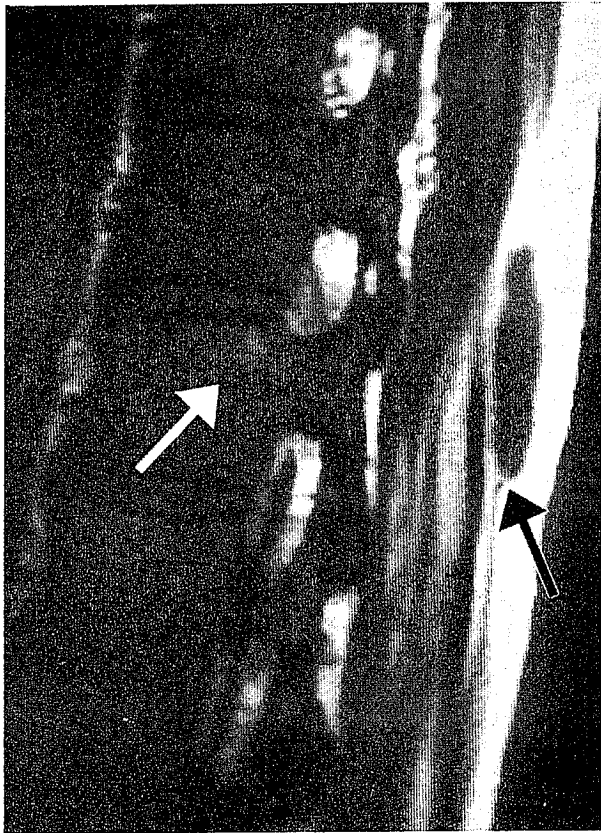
MRI of the midthoracic spine one week after presentation reveals a soft tissue abscess in the superficial planes (black arrow) with extension into the posterior aspect of the vertebral body (white arrow).
